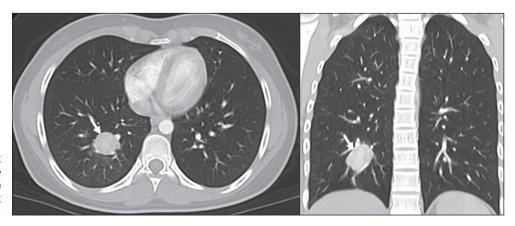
High-resolution chest computed tomography. Presence of nodule with soft tissue density in the posterior segment of the right lower lobe of 2.0 x 2.7 cm (arrow).
